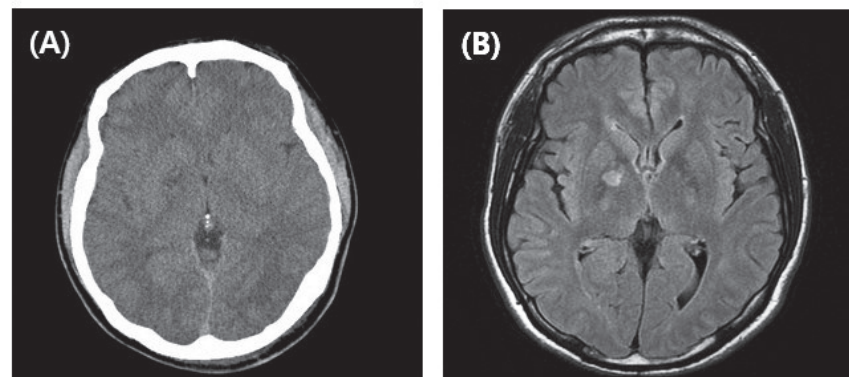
Scan images of (A) the initial brain computed tomography (CT) and (B) the brain MRI on day four of hospitalization
